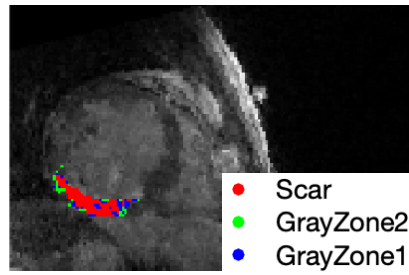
2D slice from the MRI dataset showing the heart's short axis plane with the S area marked in red and the two levels of GZ differentiated by green and blue.
